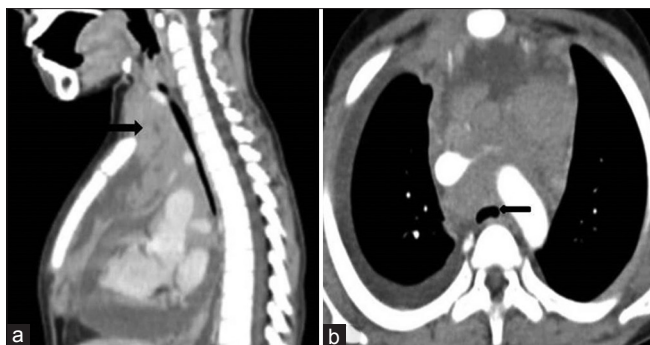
(a) CT scan (sagittal view) showing the extent of mass from C7 to T4 (b) cross sectional view showing tracheal compression
